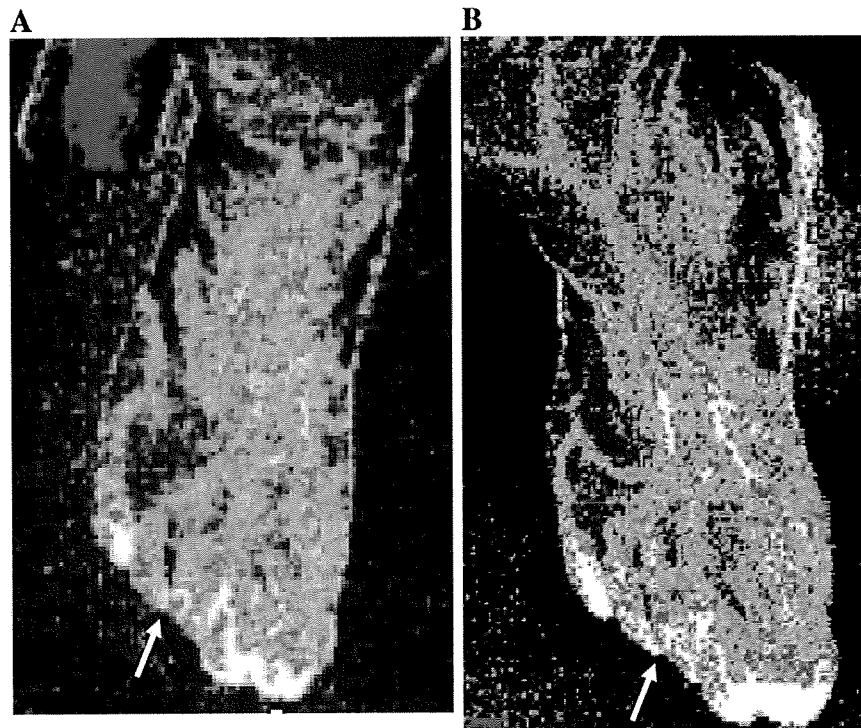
Laser Doppler imaging of right foot (A) on admission and (B) after steroid therapy. Color-coded images represent blood flow distribution. The highest perfusion is displayed as white. The steroid therapy improved the peripheral blood supply (arrows).
